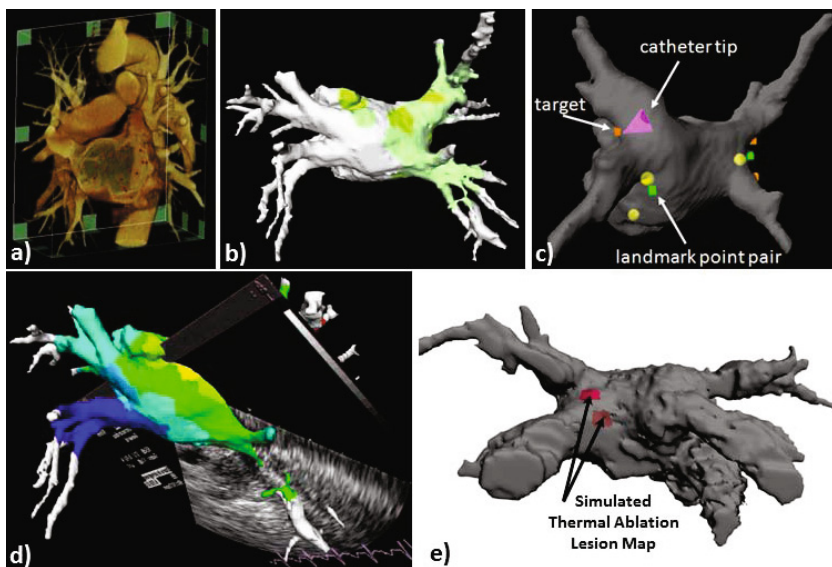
Advanced platform for image guidance and visualization for left atrial ablation therapy. a) Volume-rendered pre-operative patient-specific CT scan; b) electro-anatomical model showing superimposed activation data, integrated with real-time magnetic catheter tracking (c) and real-time tracked US imaging (d); e) proposed feature addressed in this work for effective representation and visualization of thermal model maps for therapy monitoring and guidance of successive lesions.
